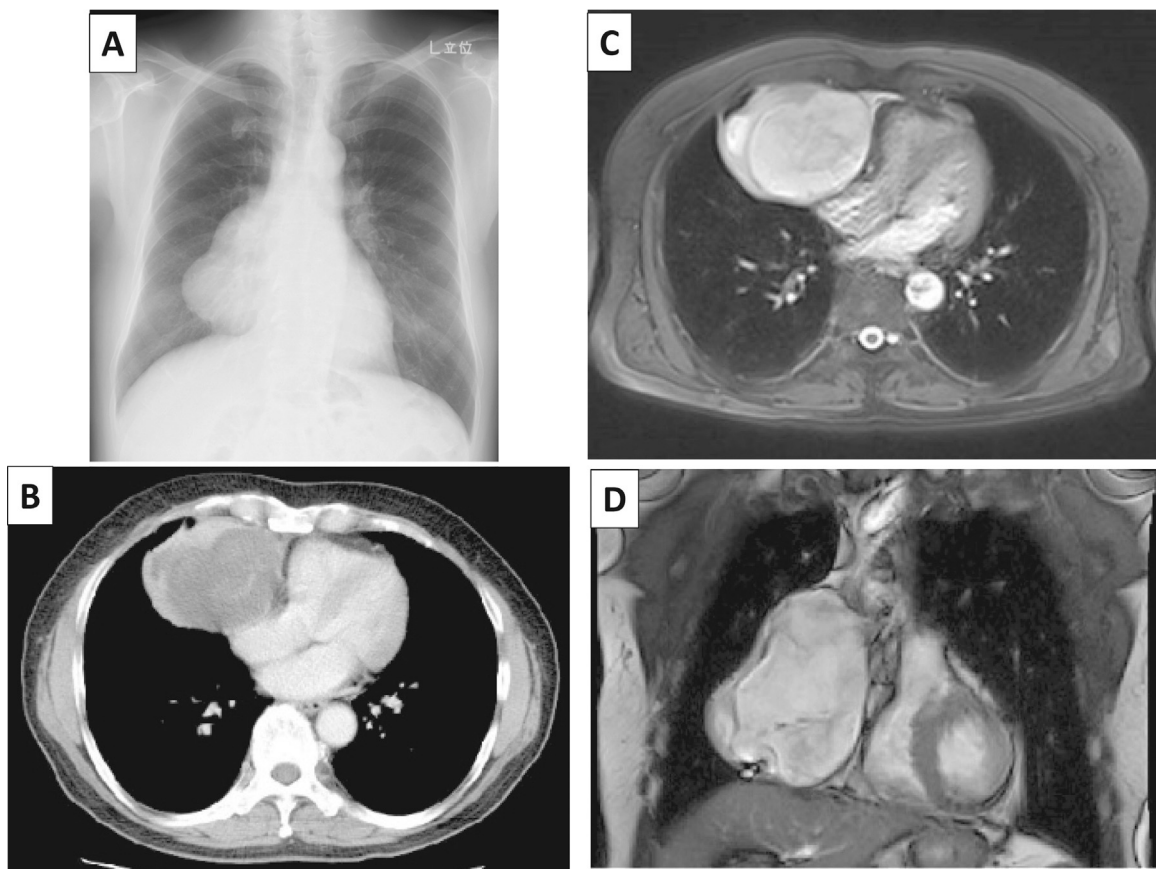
Imaging findings of the mediastinal tumor: (A) chest radiograph revealing a mass lesion in the right pulmonary hilum; (B) computed tomography (CT) scan of the chest showing a heterogeneous mass lesion with infiltrative margins in the anterior mediastinum; and (C–D) magnetic resonance imaging revealing that the mass lesion exhibits a heterogeneous high signal intensity with cystic lesions on T2-weighted images. There were no signs of adipose tissue or calcification in the chest CT or MRI findings.
